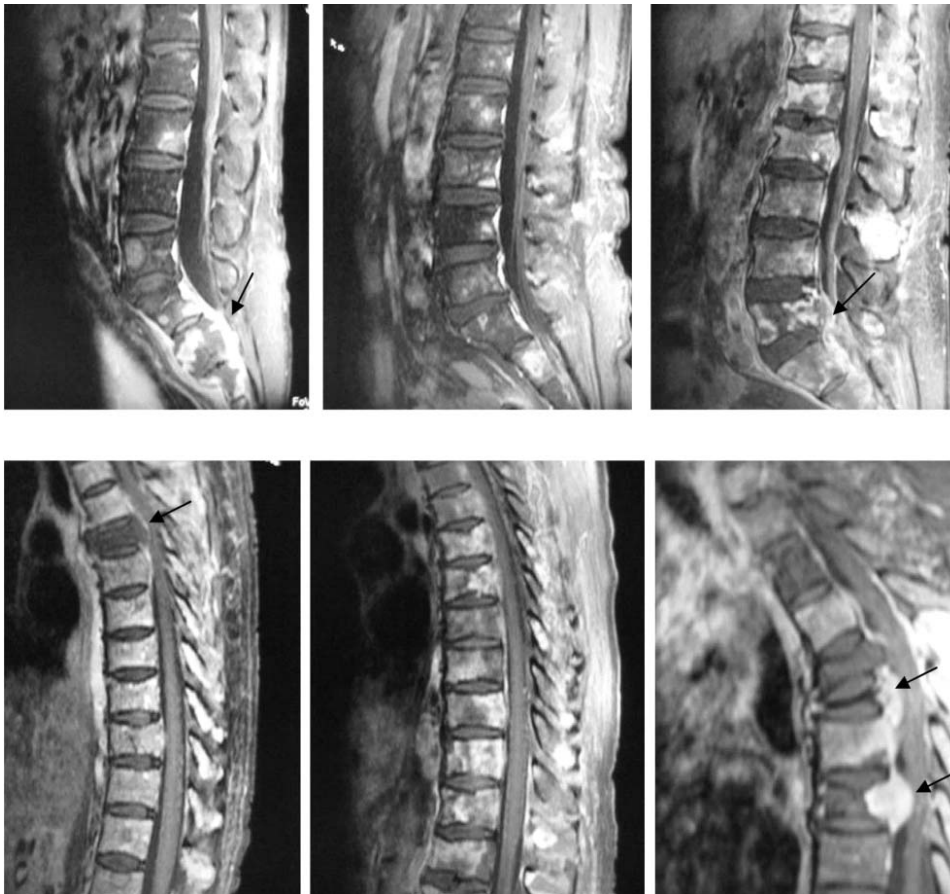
Various cases of spinal tumors (metastases) are well delineated on post gadolinium sagittal T1-weighted images with fat saturation showing enhancement of the vertebrae and spinal cord/nerve roots, without enhancement of intervertebral discs. Multiple levels of involvement are observed. Epidural extension (arrows) are seen compressing the cord or nerve roots, without abscess formation.
